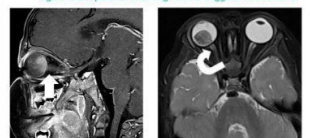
(left) Oblique sagittal T1-weighted post-contrast MRI image (right) Axial T2-weighted MRI image of a 14-month-old boy with right eye retinoblastoma. There is subtle increase in contrast enhancement (arrow) and T2-weighted hypointense signal (curved arrow) in the post-laminar segment of right optic nerve, suggestive of involvement by tumour.
